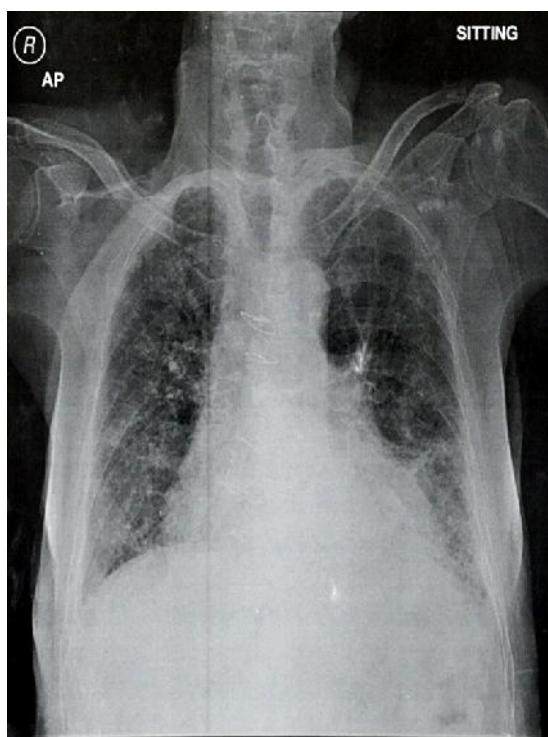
Chest radiograph of the patient indicating sternal sutures, prominent reticular markings in bilateral lung fields, predominantly in bilateral lower lobes and bilateral upper zones, blunting of left CP angle suggestive of pleural effusion.
